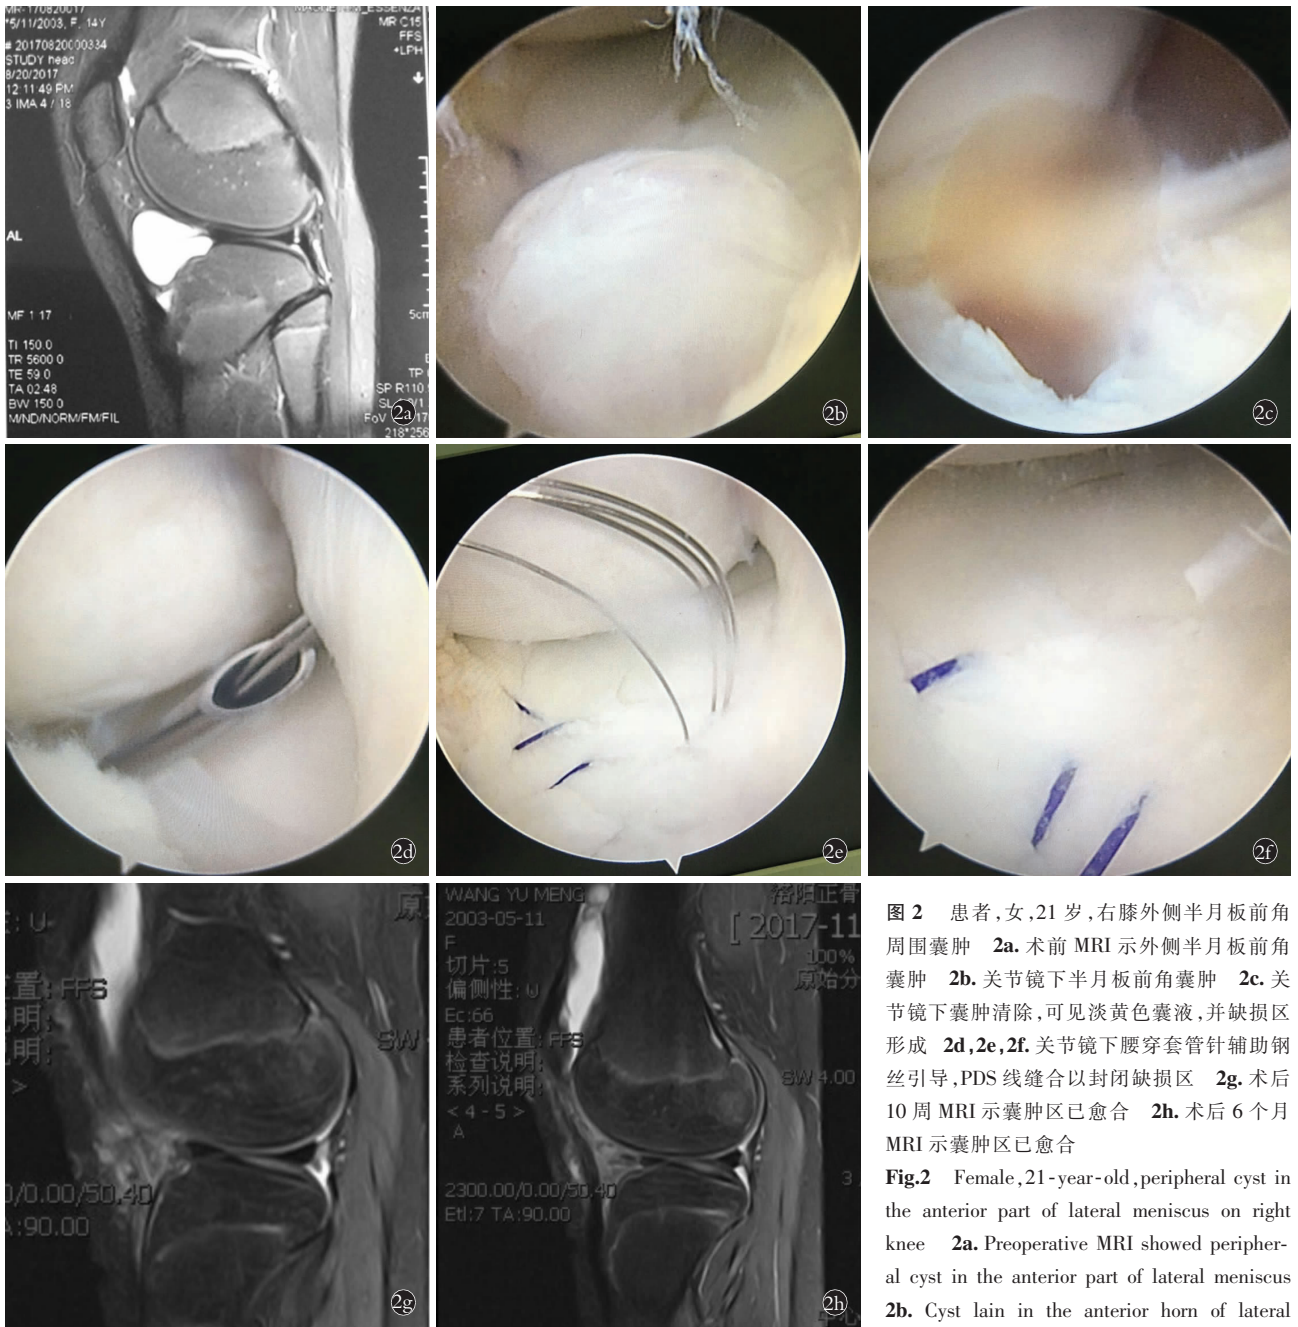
患者,女,21 岁,右膝外侧半月板前角周围囊肿 2a. 术前 MRI 示外侧半月板前角囊肿 2b. 关节镜下半月板前角囊肿 2c. 关节镜下囊肿清除,可见淡黄色囊液,并缺损区形成 2d,2e,2f. 关节镜下腰穿套管针辅助钢丝引导,PDS 线缝合以封闭缺损区 2g. 术后 10 周 MRI 示囊肿区已愈合 2h. 术后 6 个月 MRI 示囊肿区已愈合
